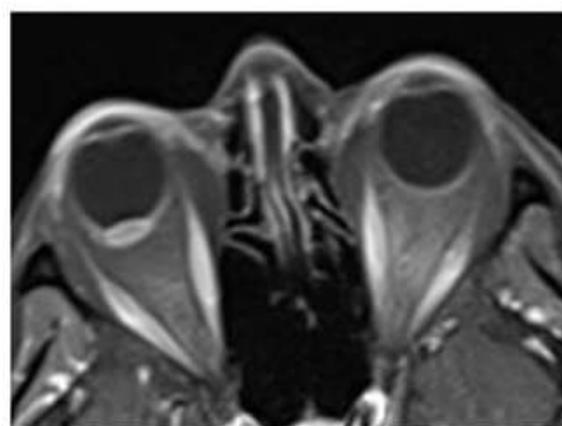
Orbital MR image
